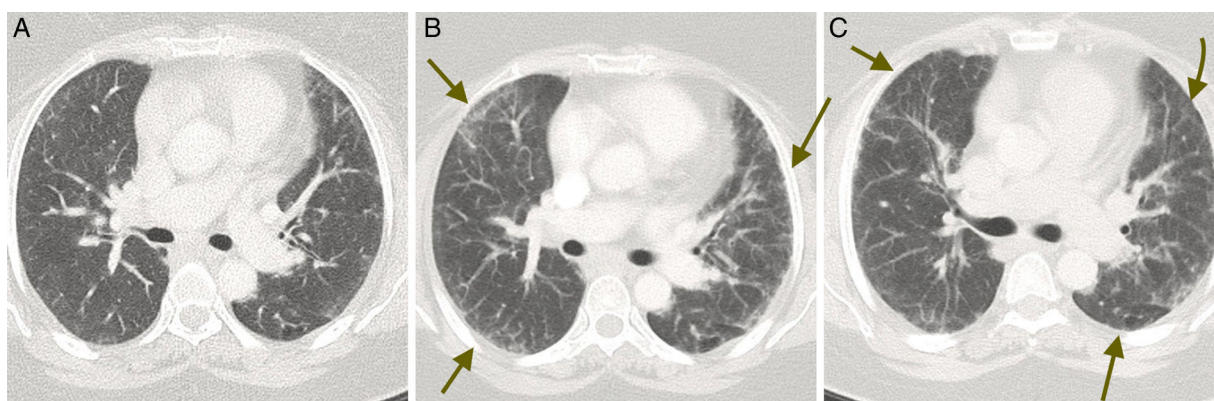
Serial computed tomography scans taken in the axial plane: (A) initial phase, (B) high point of the process and (C) resolution.
